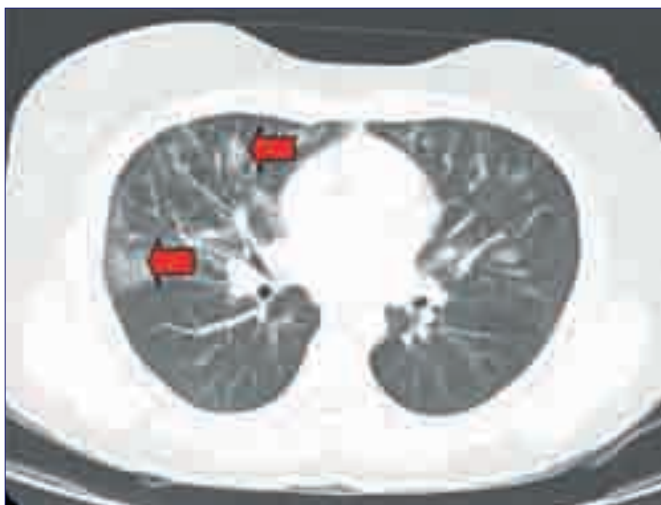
High resolution CT chest of the patient revealing ground glass opacification (red arrows)
